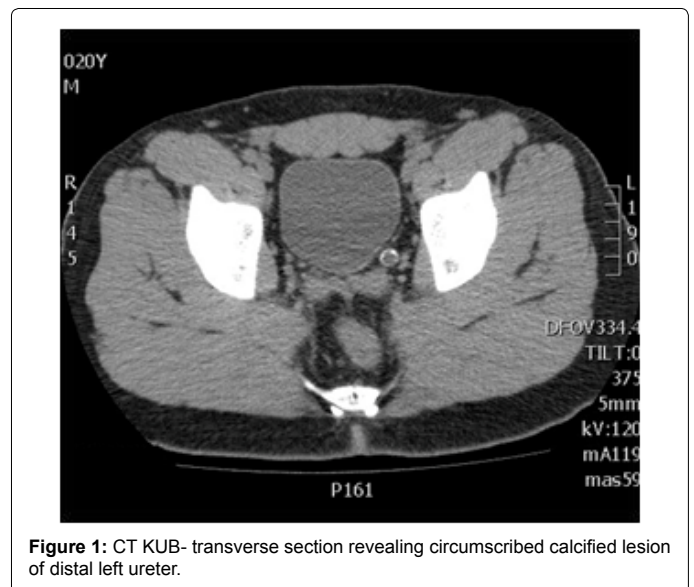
CT KUB- transverse section revealing circumscribed calcified lesion of distal left ureter.
